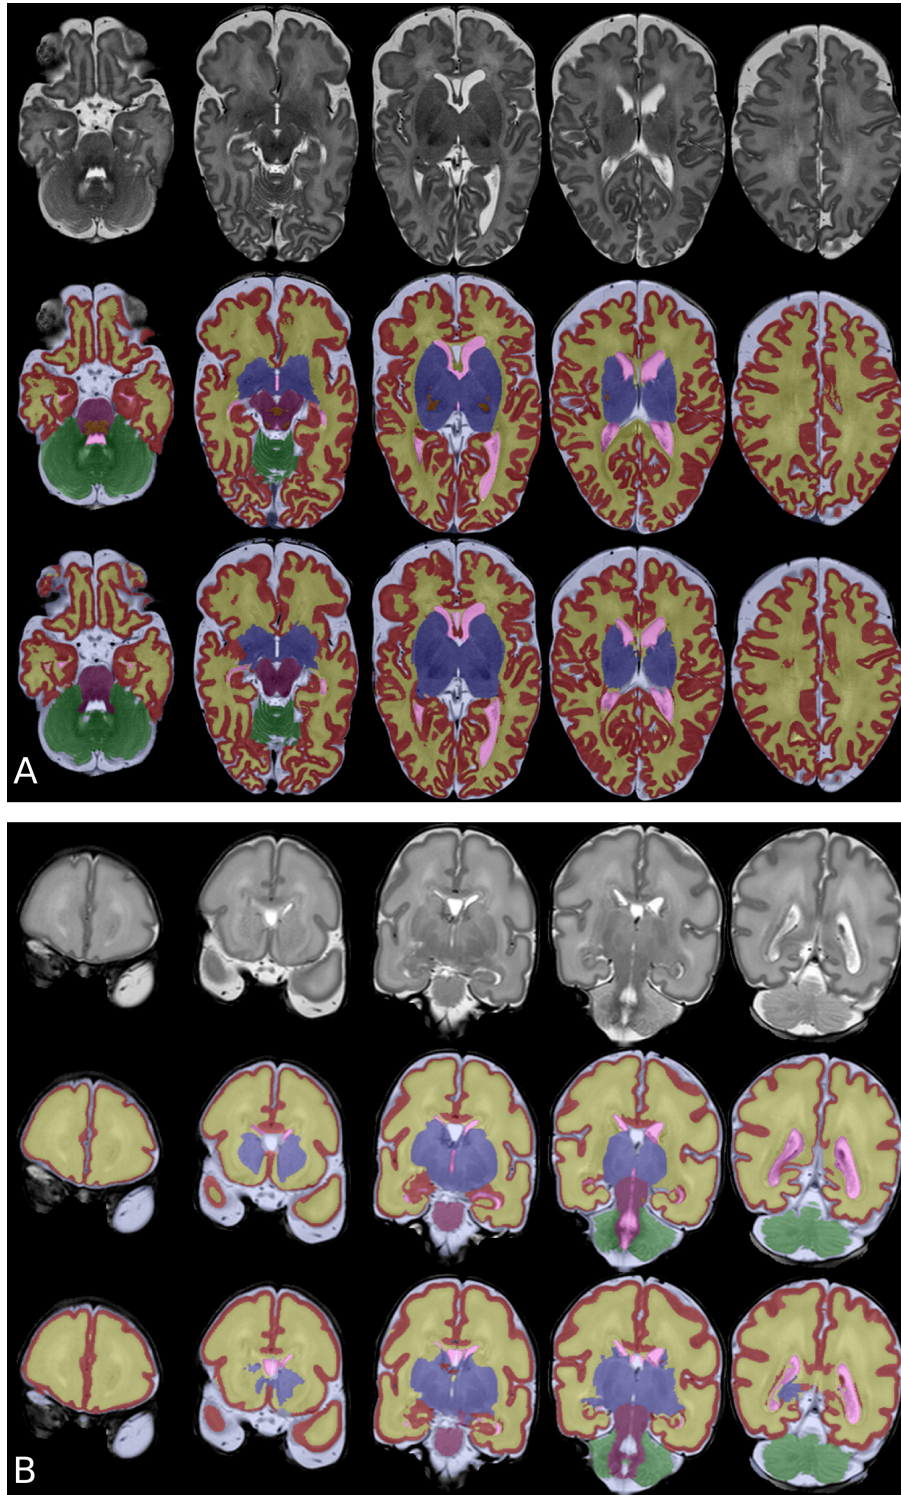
Example tissue segmentation of a neonatal MRI from Set 1 (A) and Set 2 (B) of the NeoBrainS12 challenge (second row: manual segmentation, third row: automatic segmentation).
